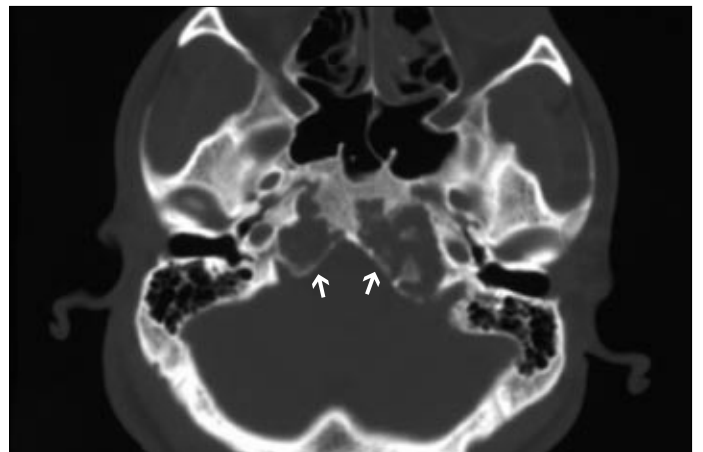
Axial computed tomography (CT) image of the skull base shows an expansile, cartilaginous mass (arrows) involving the parasellar area and petrous apices.
